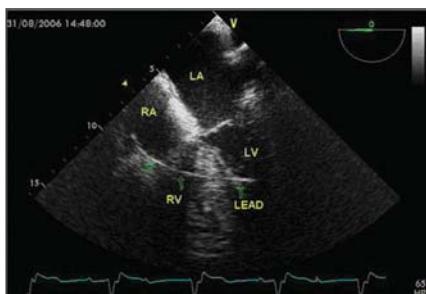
The parasternal long-axis view of transthoracic echocardiography showing the lead of the temporary pacemaker
